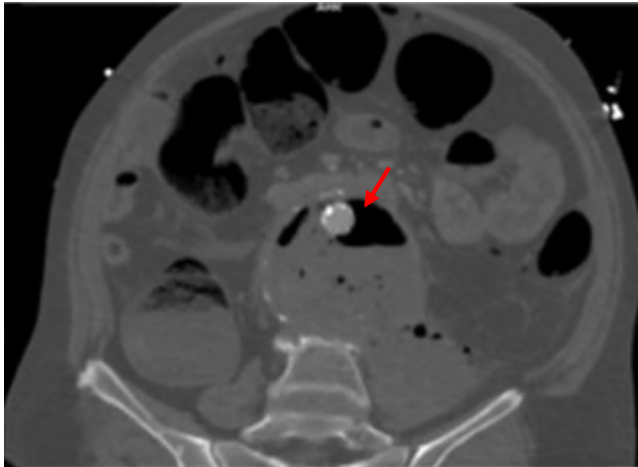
Axial view of computed tomography angiogram (CTA) demonstrating gas within the abdominal aortouniiliac stent graft (red arrow).
